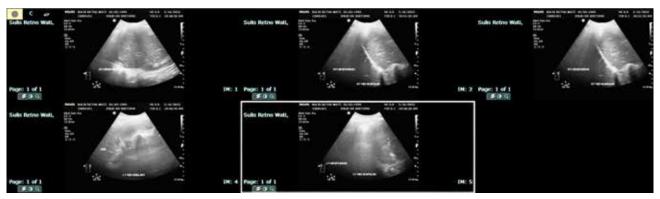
follow-up examination with an ultrasound thoracic marker.
